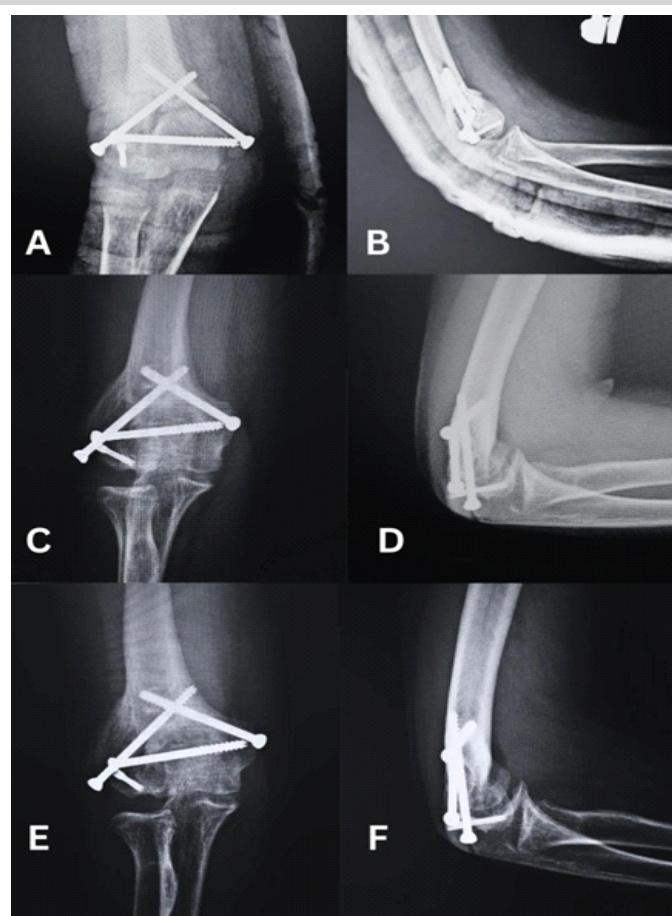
Post-operative follow-up X-ray images at (a and b) 1 month, (c and d) 6 months, (e and f) 12 months.
